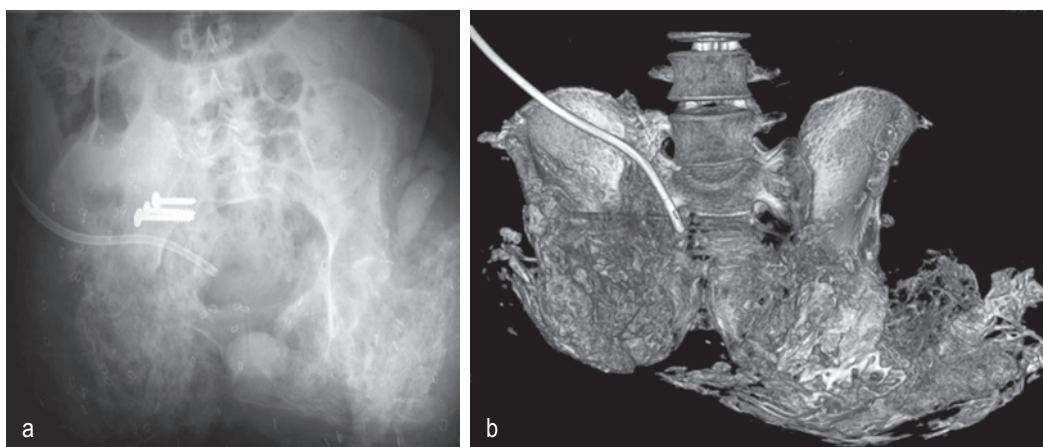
(a and b) Radiograph (a) and three-dimensional computed tomography rendering (b) of a patient with severe pelvic heterotopic ossification after bilateral hip disarticulations due to combat-related blast injuries. From Alfieri KA, Forsberg JA Potter BK. Blast injures and heterotopic ossification. Bone Joint Res. 2012;8:192–197.
